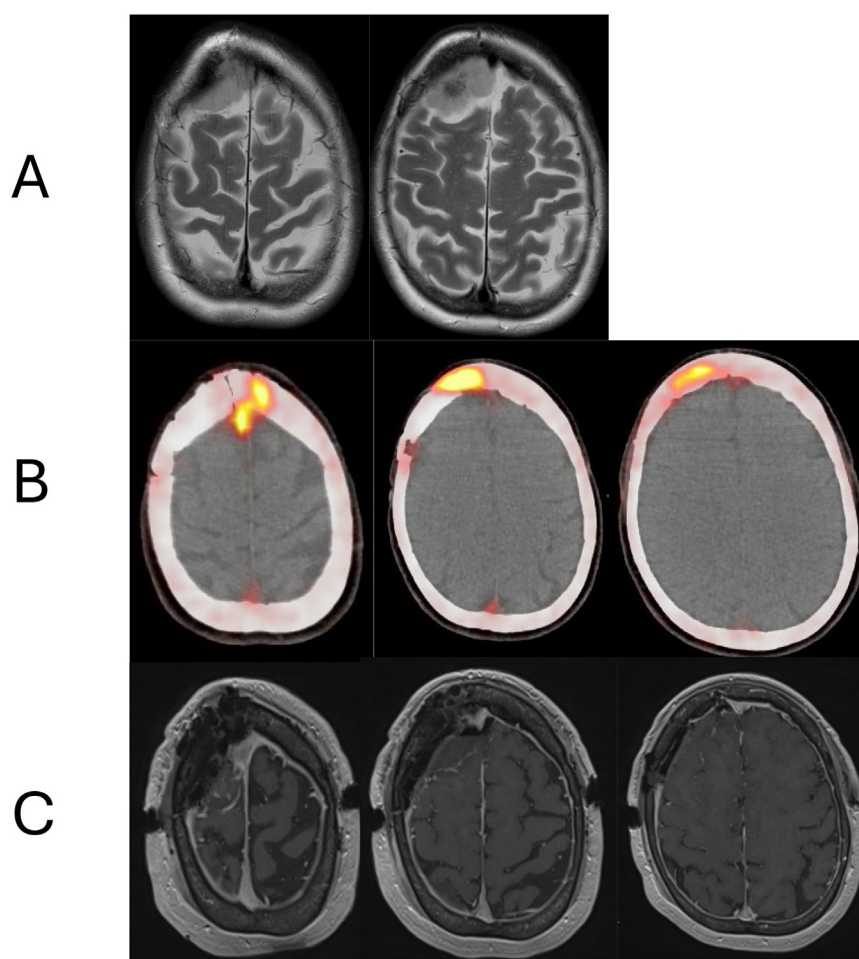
Case 4-Grade 2 with residual disease on PET and bone involvement. (A) Preoperative MRI. (B) Postoperative PET. (C) Postoperative MRI. *Abbreviations:* MRI = magnetic resonance imaging; PET = positron emission tomography.
